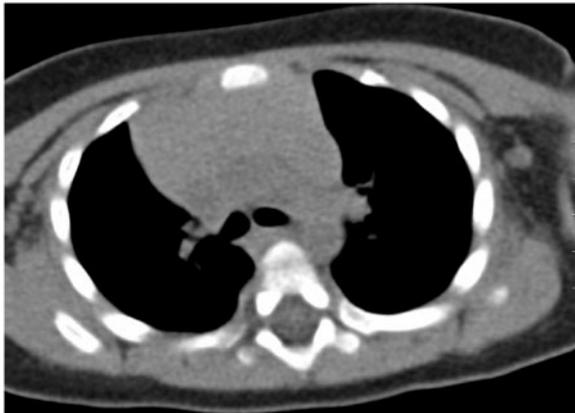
Chest radiograph showed a possible mediastinal mass in a 2-year-old child who was otherwise well. A non-contrast CT study is uninterpretable as there is no mediastinal fat present, unlike in adult patients, to outline the normal mediastinal structures. A contrast-enhanced study is thus mandatory to define the vascular anatomy in a child, and a non-contrast study is of no benefit. The abnormality on the radiograph was a normal thymus, confirmed with ultrasound. (MRI would have been a better cross-sectional examination than CT in this context).
